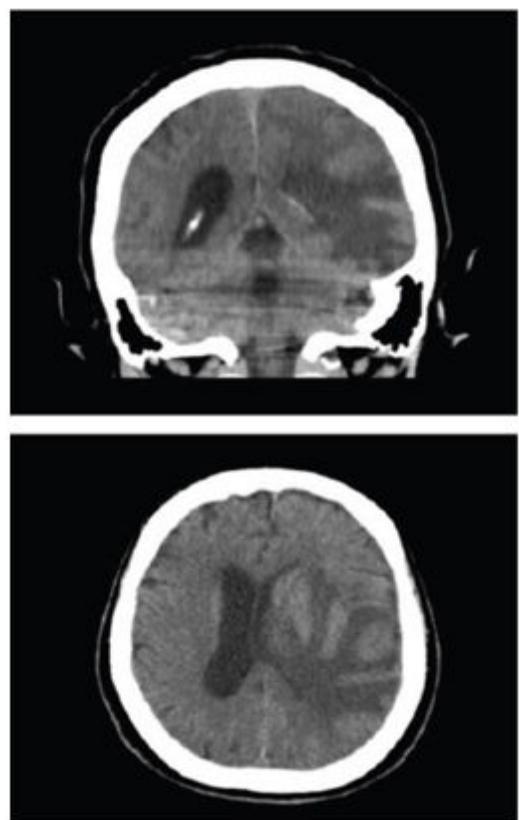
Cranial CT scan.
